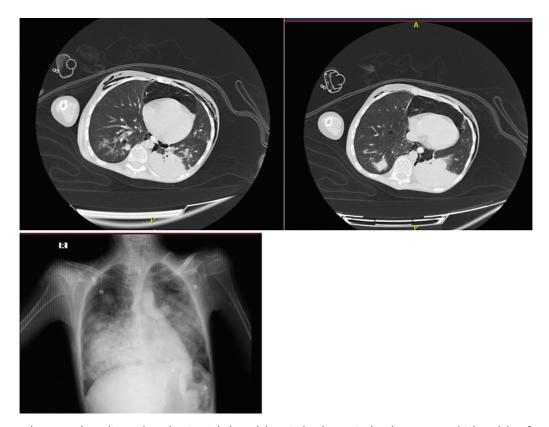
Computed tomography and X-ray chest showing right lower lobe apical and posterior basal segments multiple nodules of varying sizes in the setting of cerebellar medulloblastoma highly suggestive of metastasis.
